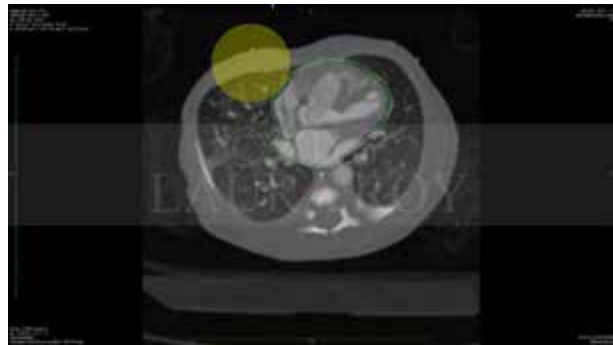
CT image slice with traced ROI (green) being adjusted by repulsor tool (yellow). (Text not intended to be read)
